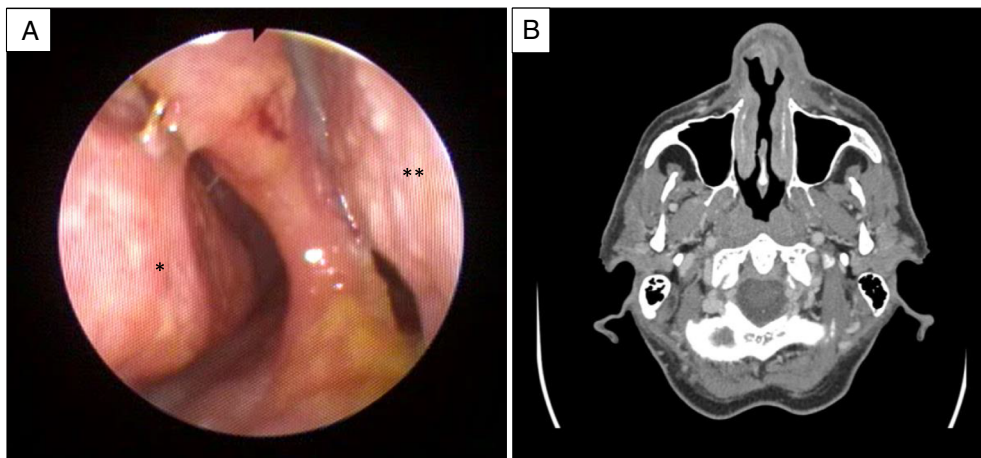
(A) Nasal endoscopy showing the septal perforation with crusting around the edges and purulent secretions (*right inferior turbinate; left inferior turbinate). (B) Axial CT scan cut with contrast showing significant cutaneous and subcutaneous inflammatory changes at the level of the nose. Note the septal perforation with no apparent sinonasal masses or collections.
